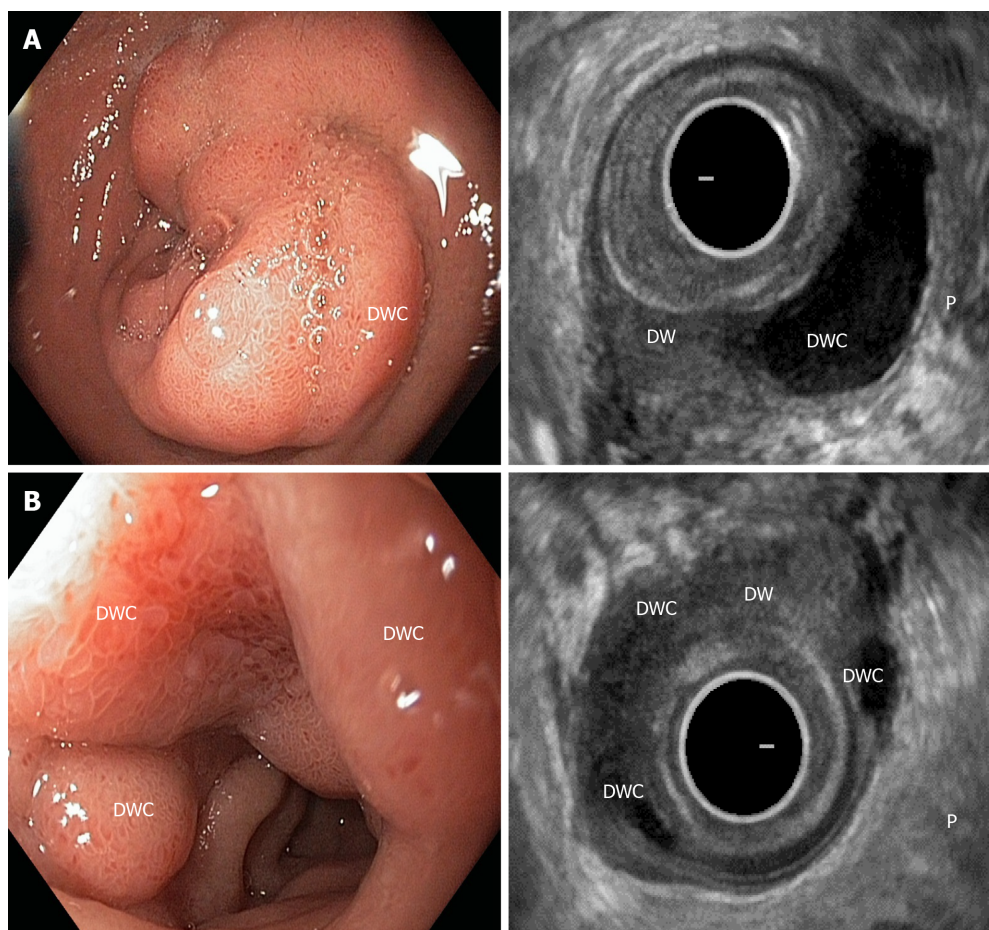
Duodenoscopy and endosonography. Isolated form of the cystic dystrophy of the duodenal wall with unchanged orthotopic pancreas (P). A: Duodenal wall cyst (DWC) within the submucosa and muscularis of the diffusely thickened duodenal wall (DW); B: Multiple DWCs in the submucosa and muscularis surrounding the major papilla in the diffusely thickened DW. DWC: Duodenal wall cyst; DW: Duodenal wall.
